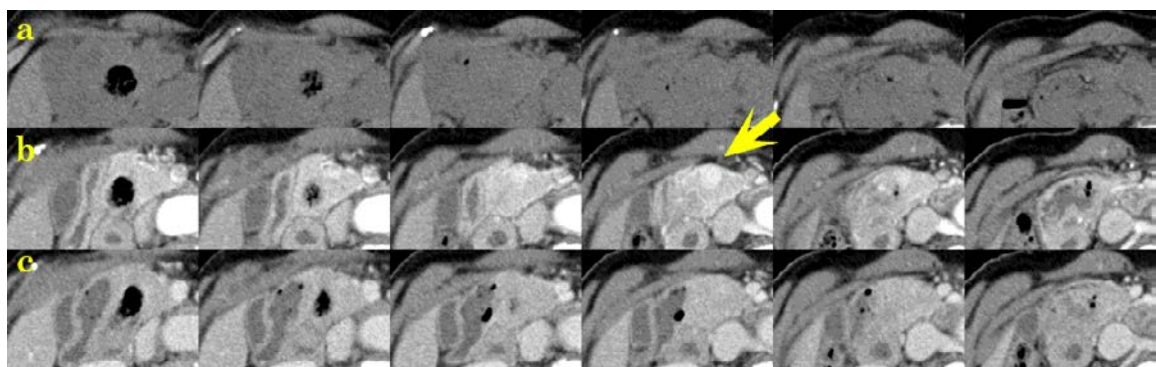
Axial CT scan of patient 2 (slice thickness: 3 mm) at 0 seconds (pre-contrast) (a), 45 seconds (b), and 80 seconds (c) after the administration of contrast agent, respectively. Only in one slice of the 45-second scan, a 9 mm high density lesion in the pancreatic head is demonstrated (indicated by a yellow arrow), whereas the same slice in the 80-second scan shows no abnormality.
